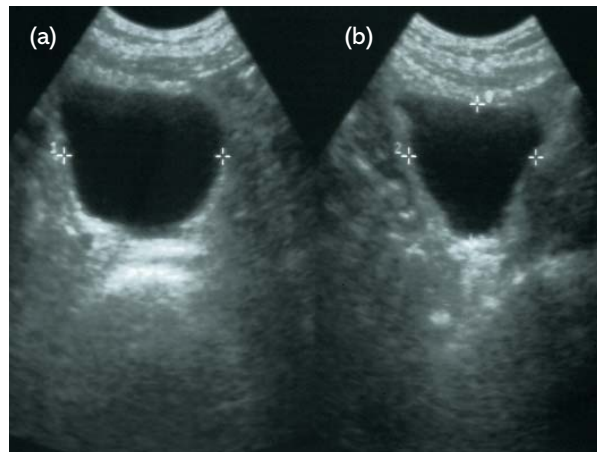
Ultrasound scans showing the bladder (a) before micturition and (b) after micturition, with a large residual volume. The cursors (+) mark the bladder-wall boundaries.
